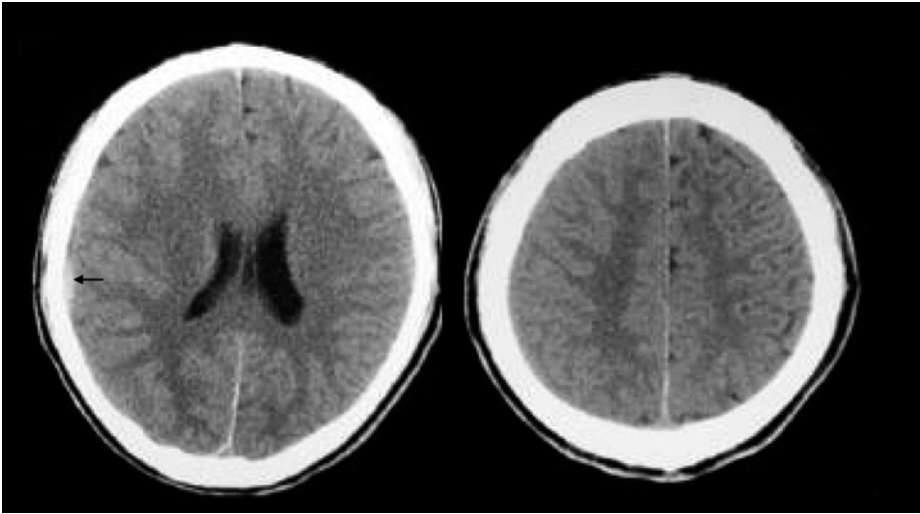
CT scan showing a thin rim of acute subdural hematoma (arrow) associated with hemispheric swelling
